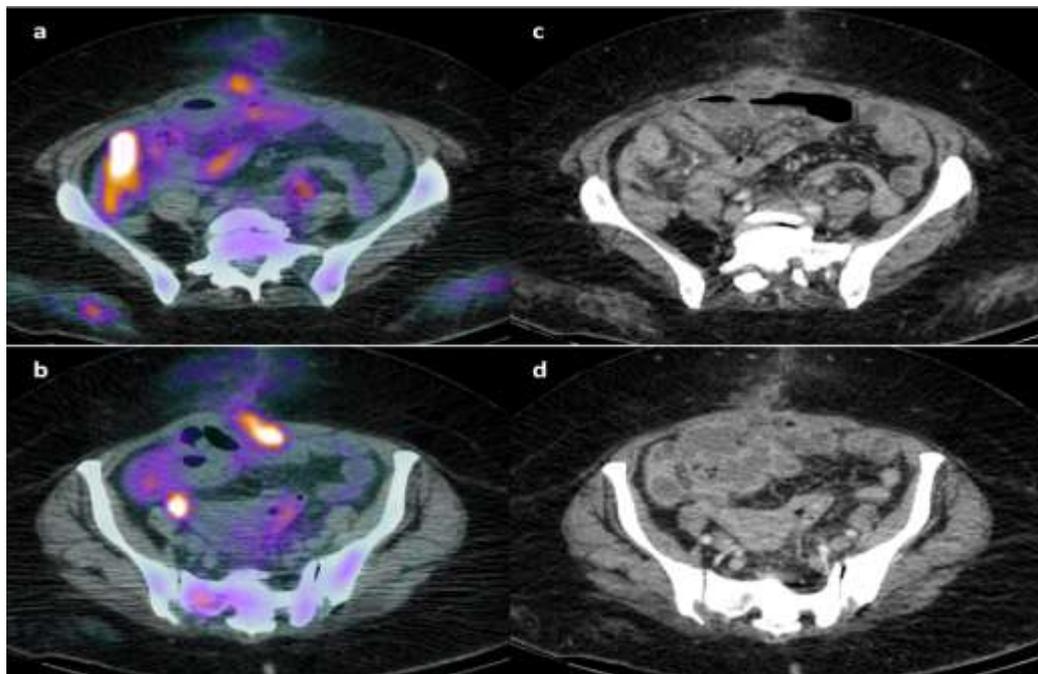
45-year-old female patient Papillary serous adenocarcinoma underwent surgery and chemotherapy, referred for post chemotherapy follow-up. CA-125 was normal. Axial fused PET/CT (a and b) and Ce-CT images (c and d). PET/CT revealed metabolically active peritoneal nodules on bowel serosa, mesocolon (a) and in pelvic cavity and small < 1 cm pelvic (b). None of these lesions was appreciable in Ce-CT (c and d)
